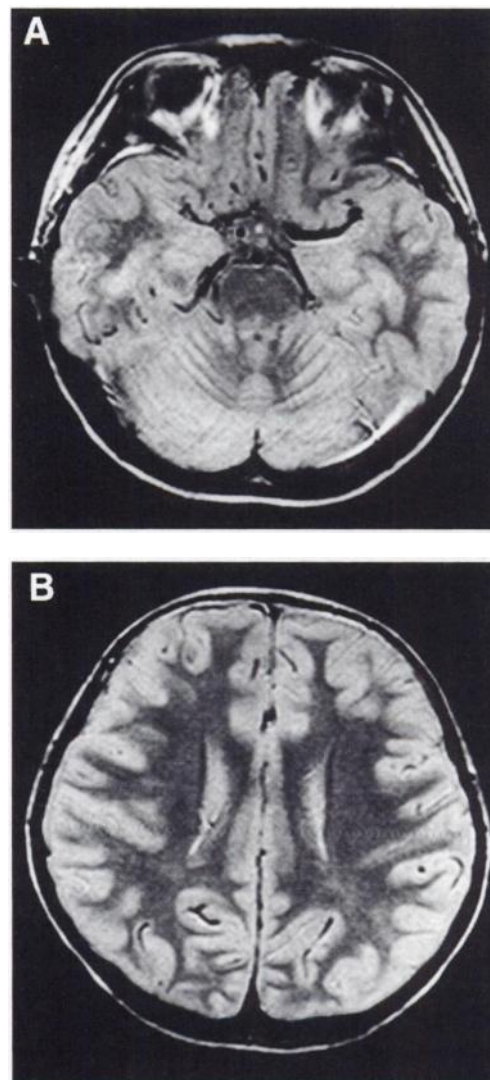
MRI shows probable right middle cerebral artery obstruction (A), but no ischemic lesions could be observed (proton density-weighted images) (B).
